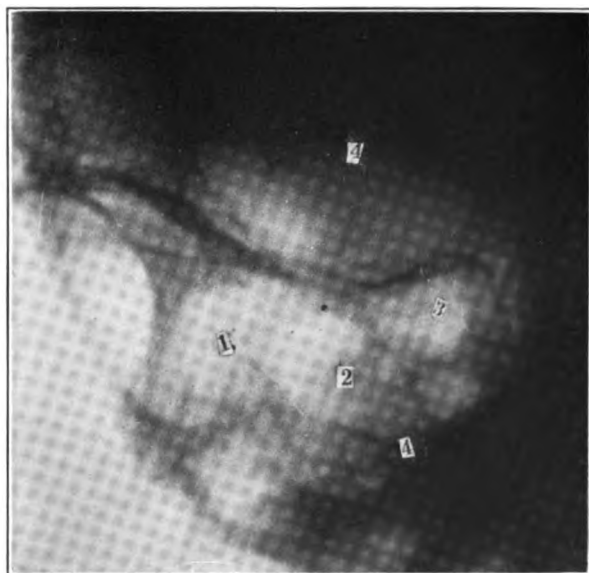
Roentgenogram showing 1, anterior and 2, posterior ethmoiditis; 3, normal sphenoid; 4, orbital margin. Note blurring in diseased areas (left side).
